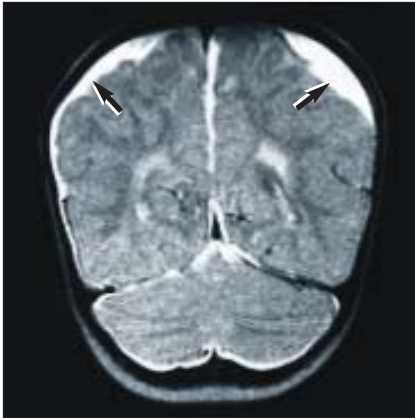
Coronal T2-weighted image demonstrating bright signal in bilateral subdural hematomas along parietal convexities (arrows).
